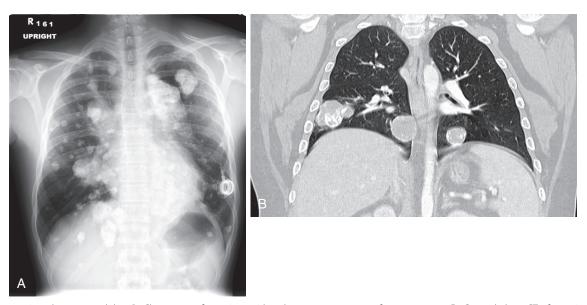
Metastatic pulmonary nodules. A, Chest x-ray of a patient with pulmonary metastases of osteosarcoma. B, Coronal chest CT of a patient with pulmonary metastases of osteosarcoma.
